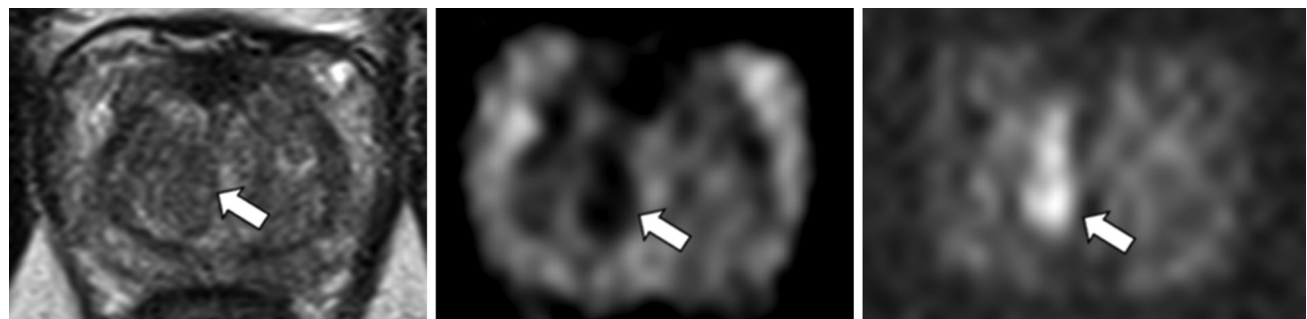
T2 axial, apparent diffusion coefficient (ADC), and diffusion-weighted imaging (DWI) axial sections showing partially encapsulated nodule in the right transition zone with Prostate Imaging Reporting and Data System (PI-RADS) score 2 with DWI score 4, which can be upgraded to PI-RADS 3 final category.
